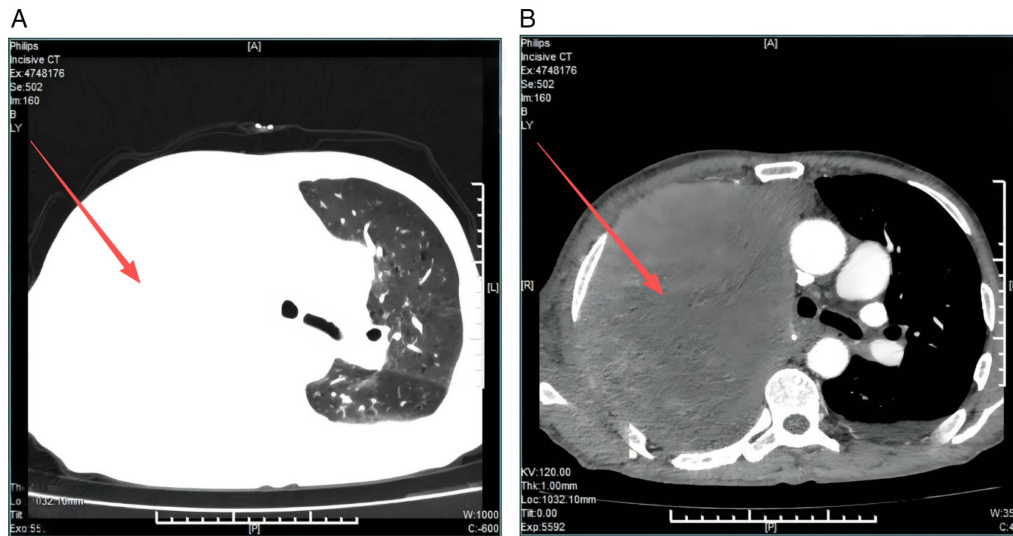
Computed tomography of the chest. (A) Lung window indicates a mass in the right lung (measuring $\sim 147 \times 113$ mm). (B) Mediastinal window shows no evidence of calcification. The affected area has been marked with arrows.
